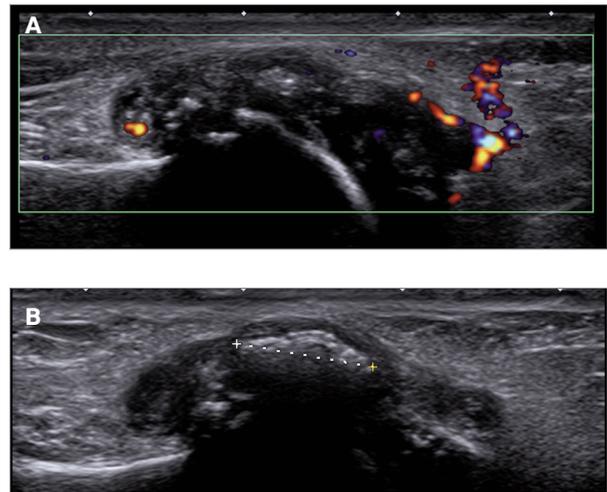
Ultrasound features of an early gout: a) a “starry sky” sign; b) micro-tophi (between crosses)
